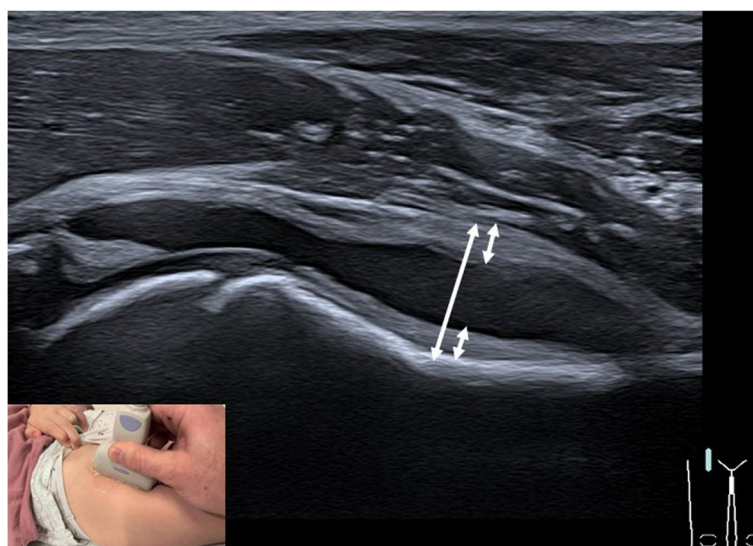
Ultrasound measurement of the anterior recess size, anterior and posterior capsula thickness. Example of anterior recess size, including the anterior and posterior capsula thickness in the anterior longitudinal view
